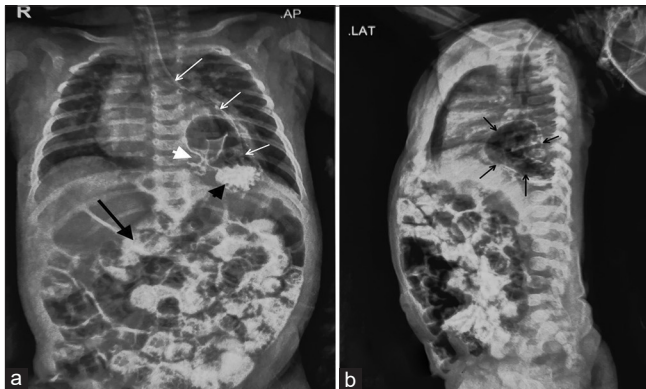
(a) A chest X-ray AP view post-contrast. Stomach bubble is absent in the abdomen. White arrows trace the orogastric tube, which ends in the left thorax. Contrast delineates the anatomy of the stomach, which is present in the thorax. The black arrowhead points to the contrast material in the stomach fundus. White arrowhead points to the pylorus of the stomach. Contrast can also be seen in the intestine (black arrow). (b) A chest X-ray lateral view post-contrast. The black arrow points to the stomach, which is posterior to the heart shadow. Contrast can also be seen in the intestine.
